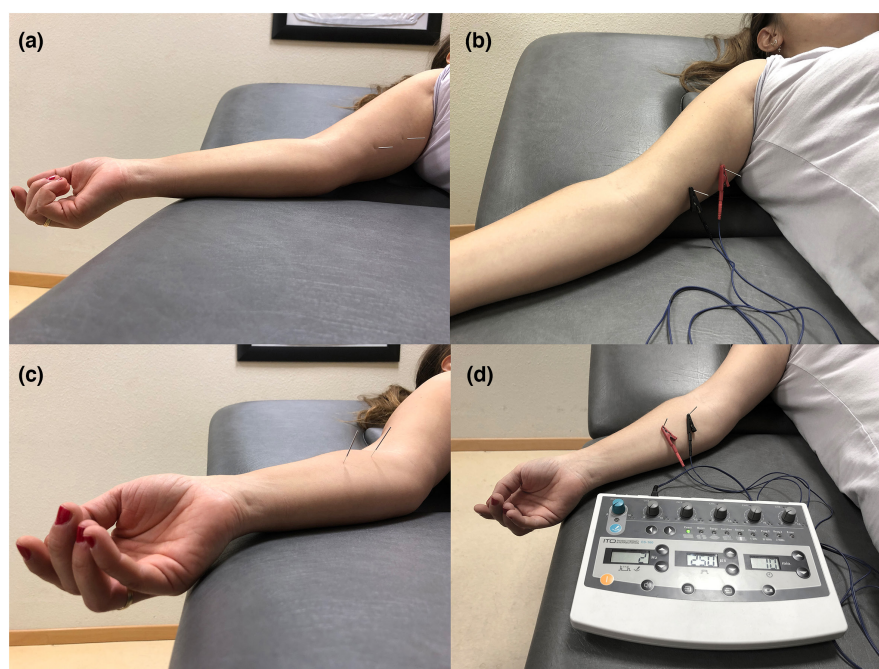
Application of ultrasound-guided percutaneous electrical stimulation on the patient on the arm (a, b) and forearm (c, d) points.
